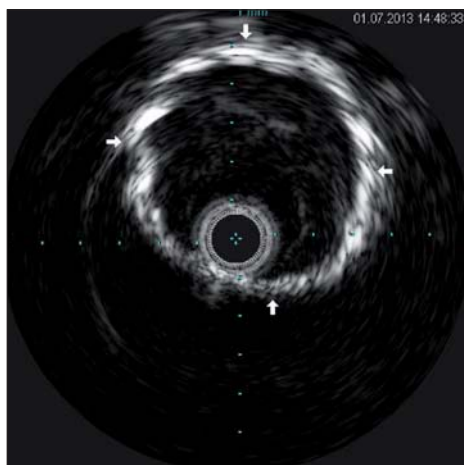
Intravascular ultrasound image showing four quadrant calcification of the superficial femoral artery in a patient with media sclerosis (courtesy Prof. Zeller, Bad Krozingen).
